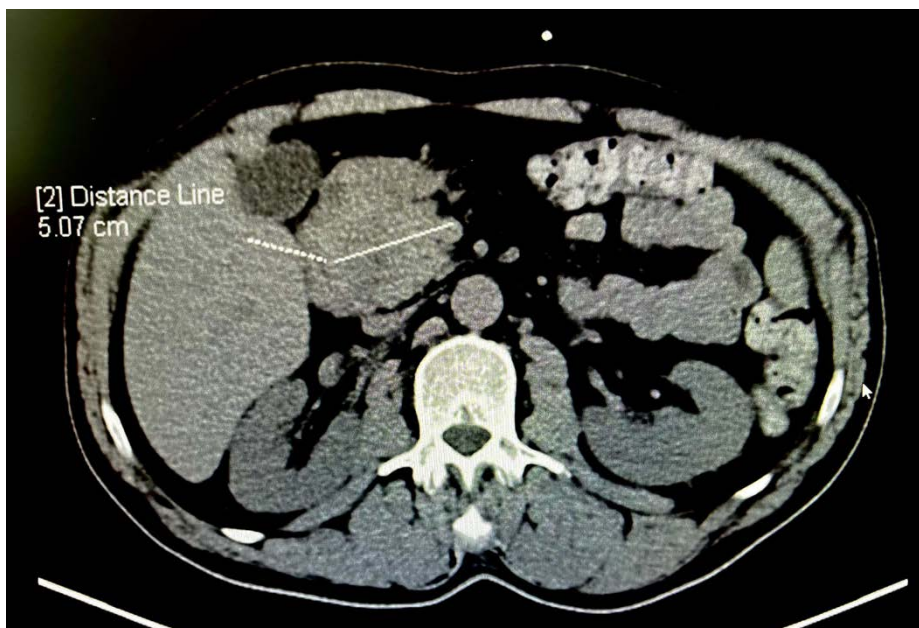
Computed tomography examination – Large well-defined hypodense lesion in the duodeno-pancreatic region and left side of the liver.
